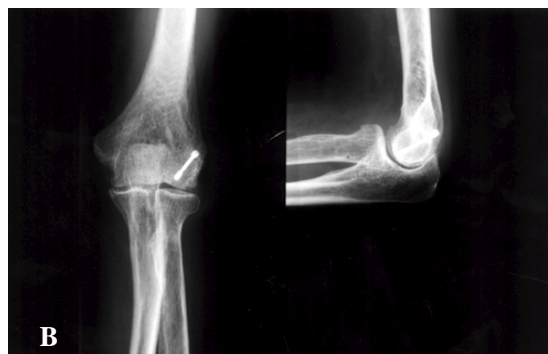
Anteroposterior and lateral radiographs of the right elbow. (A) The initial radiograph. The type I fracture of the capitellum is noticed. (B) The postoperative radiograph. The fragment of the fracture is fixed with one Herbert screw.
